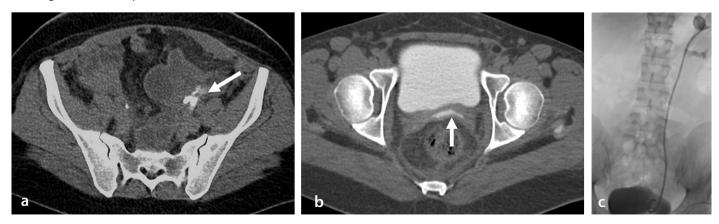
A 33-year-old woman underwent an emergency hysterectomy for postpartum hemorrhage. On follow-up, she developed left flank pain and fever. CT urography demonstrated contrast extravasation (a, arrow) and ureterovaginal fistula (b, arrow). Percutaneous nephrostomy was initially performed. Four days after nephrostomy, ureteral stent placement was performed (c). During the procedure, ureteral stricture was evident at the level of the pelvic brim (not shown). The ureteral stent was removed on the second exchange period due to the absence of stricture or leak. CT, computed tomography.
